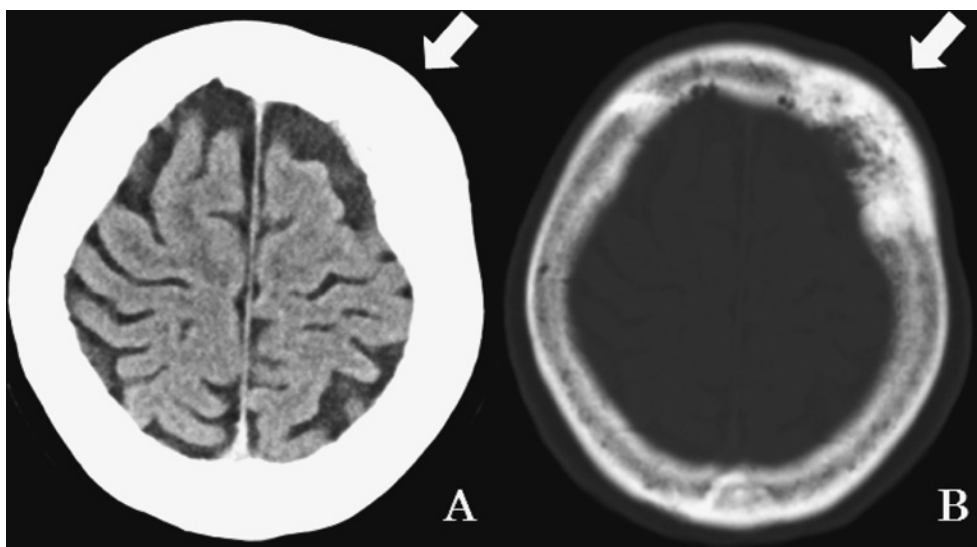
Computed tomography (CT)
